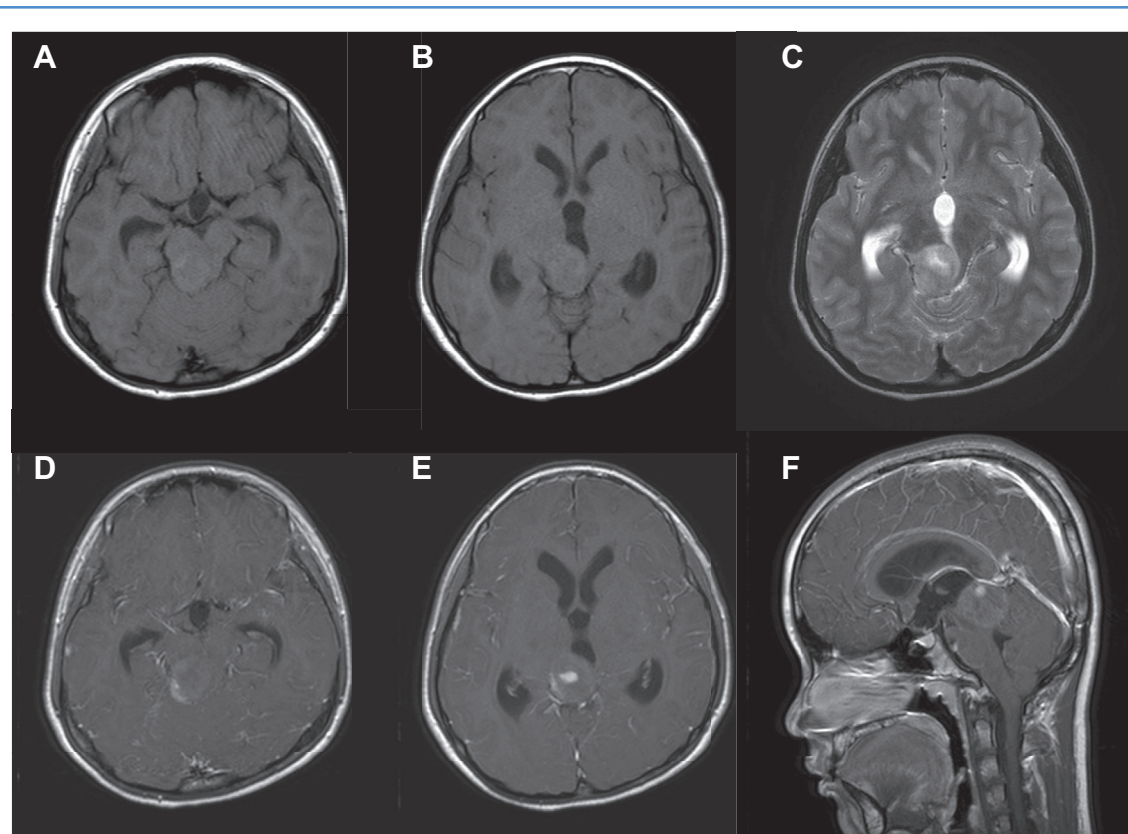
Preoperative magnetic resonance imaging (MRI). (A and B) Axial T1-weighted images; (C) axial T2-weighted image; (D and E) gadolinium-enhanced, T1-weighted axial images; (F) gadolinium-enhanced T1-weighted sagittal image. The relatively well-circumscribed midbrain lesion arising in the tectum
